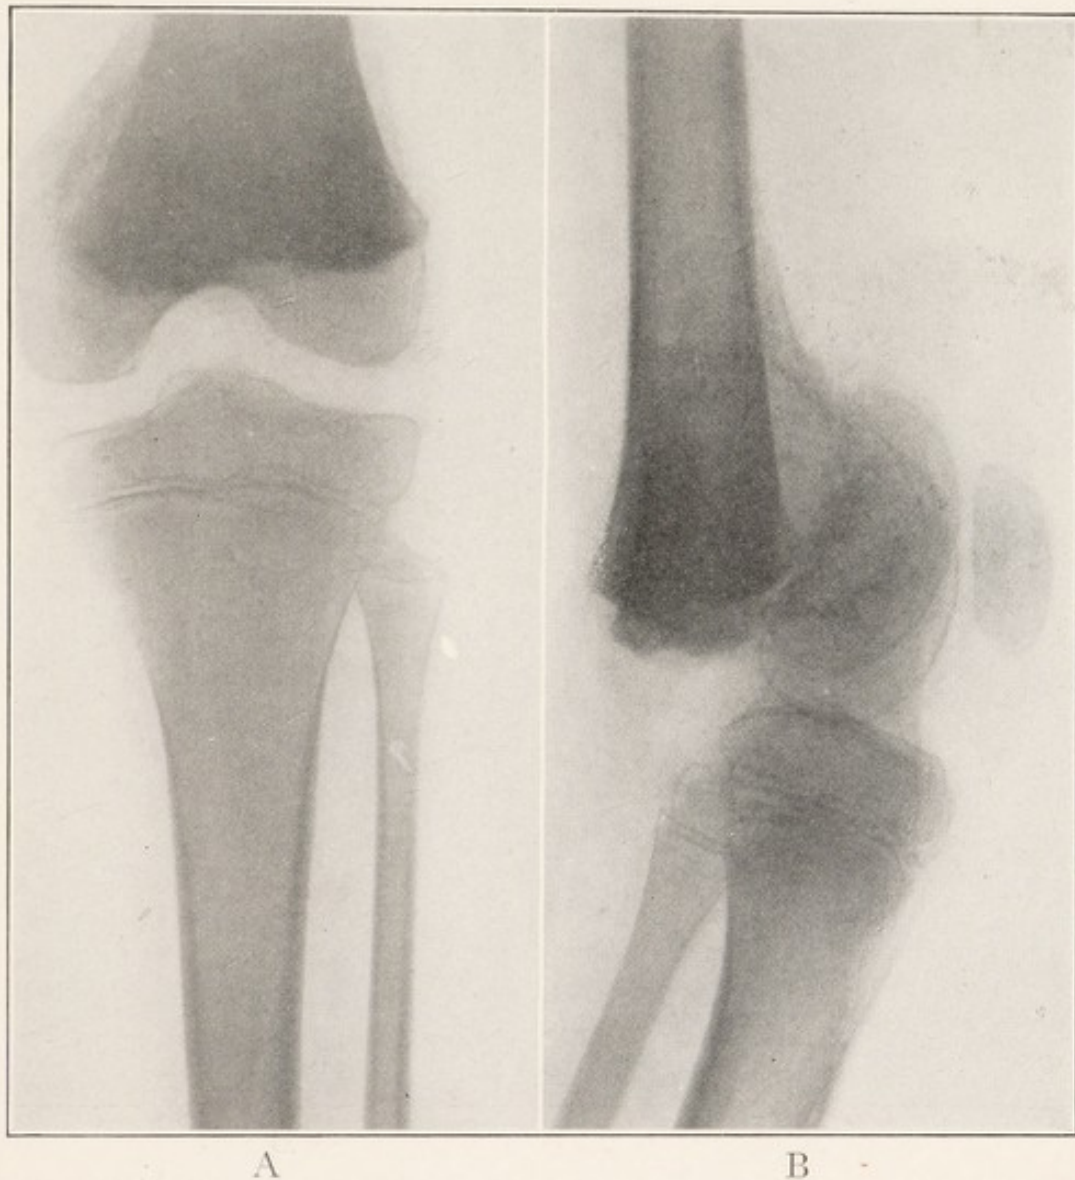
X-RAY SHOWING SEPARATION OF LOWER FEMORAL EPIPHYSES, ANTEROPOSTERIOR VIEW.
